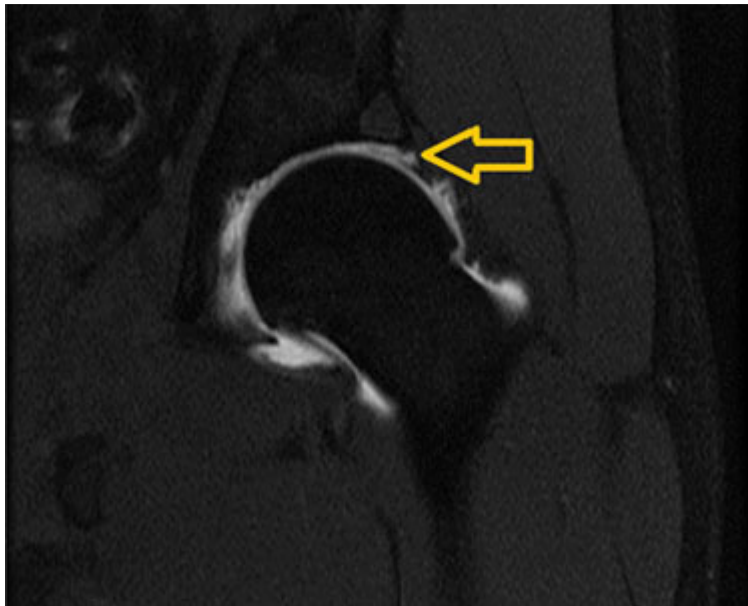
MRI arthrogram of a left hip labral tear. Arrow points to the dye leaking between the labrum and the articular cartilage.
